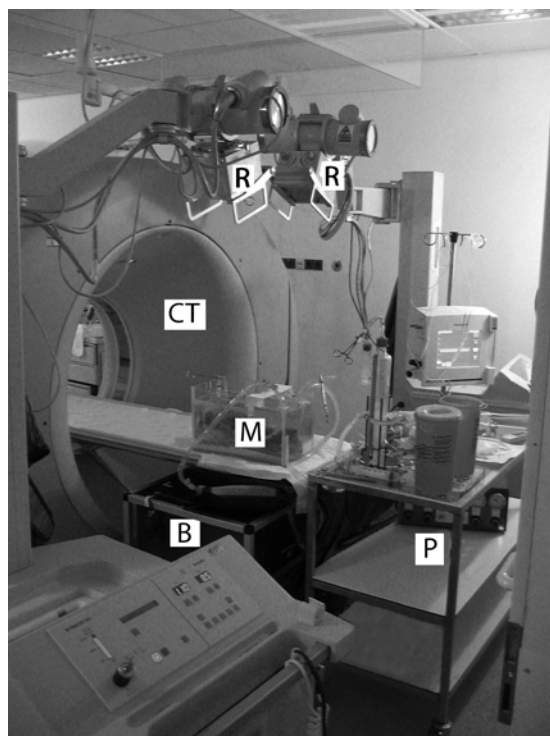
Experimental setup. The model (M) is placed on the CT table. Imaging can be switched between RSA and CT without disturbing the model. The physiological flow and pulsatility is generated with an artificial circulation (P). The RSA setup is positioned next to the CT gantry (CT). Two crossing X-ray beams from the 2 Roentgen foci (R) expose the films under the calibration box (B).
